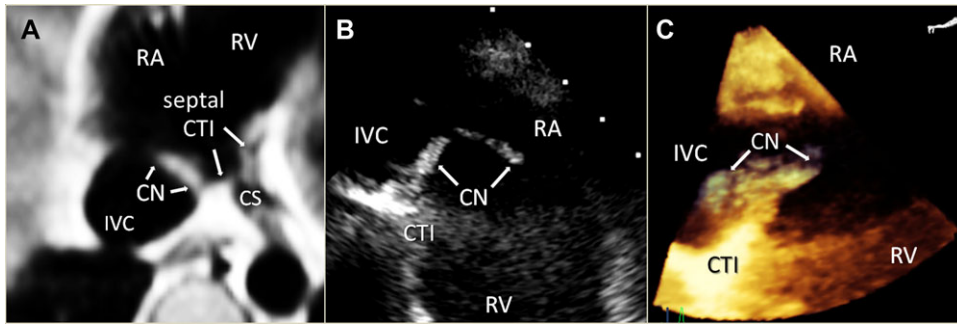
Periprocedural visualization of the area of radiofrequency bipolar ablation. Magnetic resonance (A), 2-dimensional (B), and 3-dimensional (C) transesophageal echocardiography show the presence of enlarged Chiari's network (CN) originating from cavotricuspid isthmus (CTI). CS = coronary sinvvus; IVC = inferior vena cava; RA = right atrium; RV = right ventricle. For a high quality, full color version of this figure, please see Journal of Cardiovascular Electrophysiology's website: www.wileyonlinelibrary.com/journal/jce
